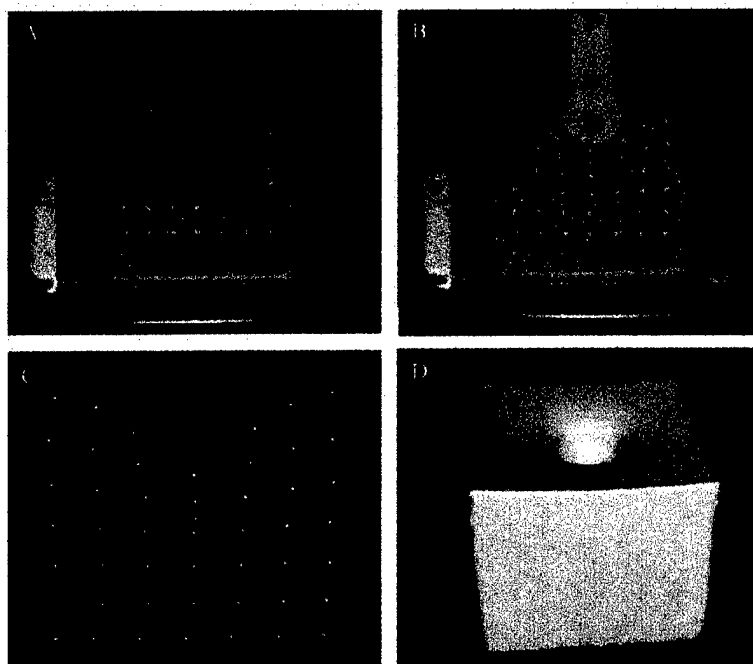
CT of center vertical slice for spherical indentation in unloaded state (A) and under 30% nominal strain (B). Note the registration marker off to the side. The trajectory and locations of the internal spheres for the same slice is shown in (C) where blue represents no indentation, the 22% nominal strain case is shown in green, and the 30% nominal strain case in yellow. The surface for the 30% strain case is represented in (D).
